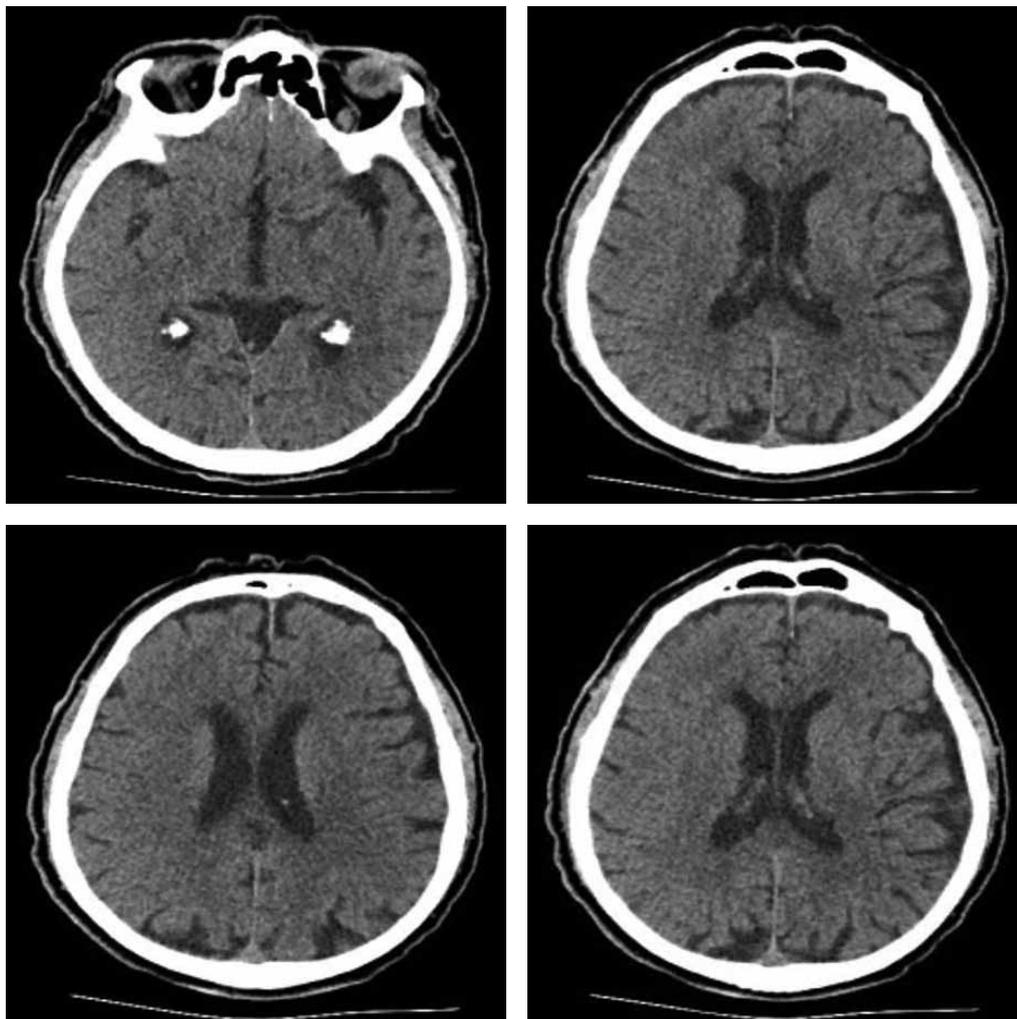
Brain CT demonstrated no abnormalities.
